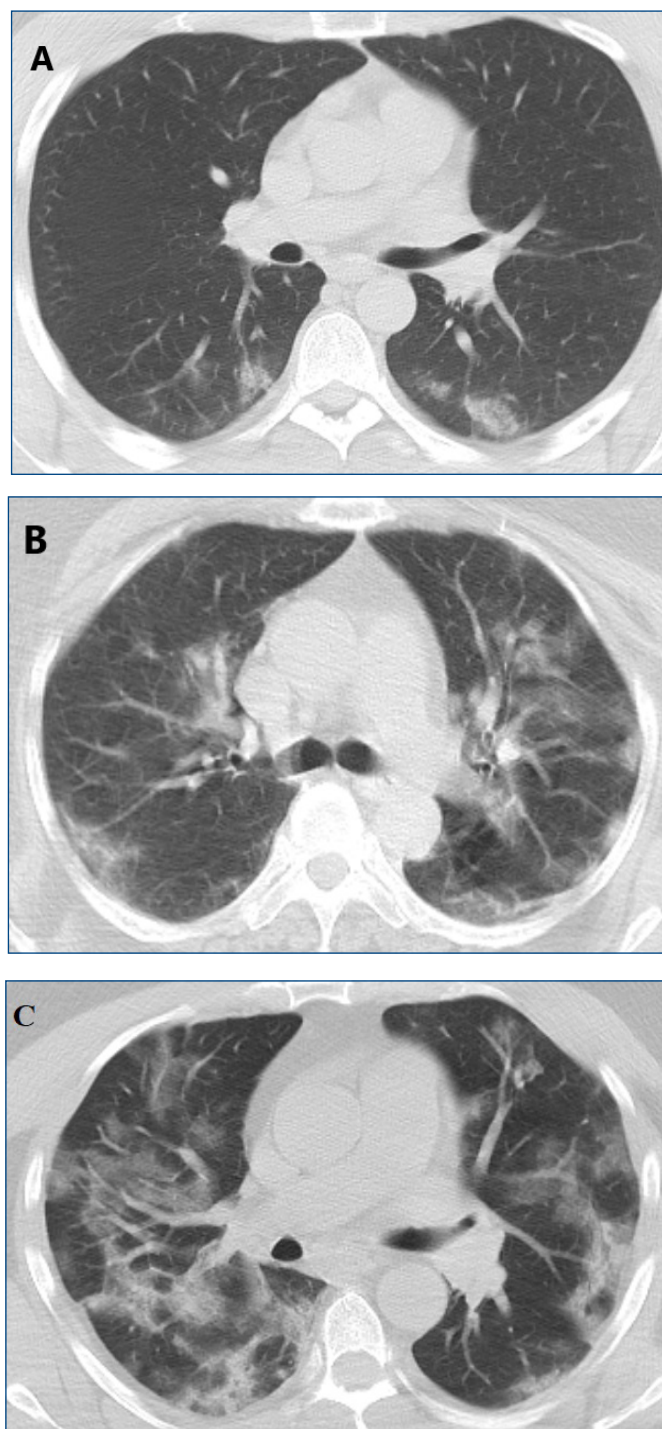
CT sections of different patients with mild (A), moderate (B), and severe (C) pneumonia
